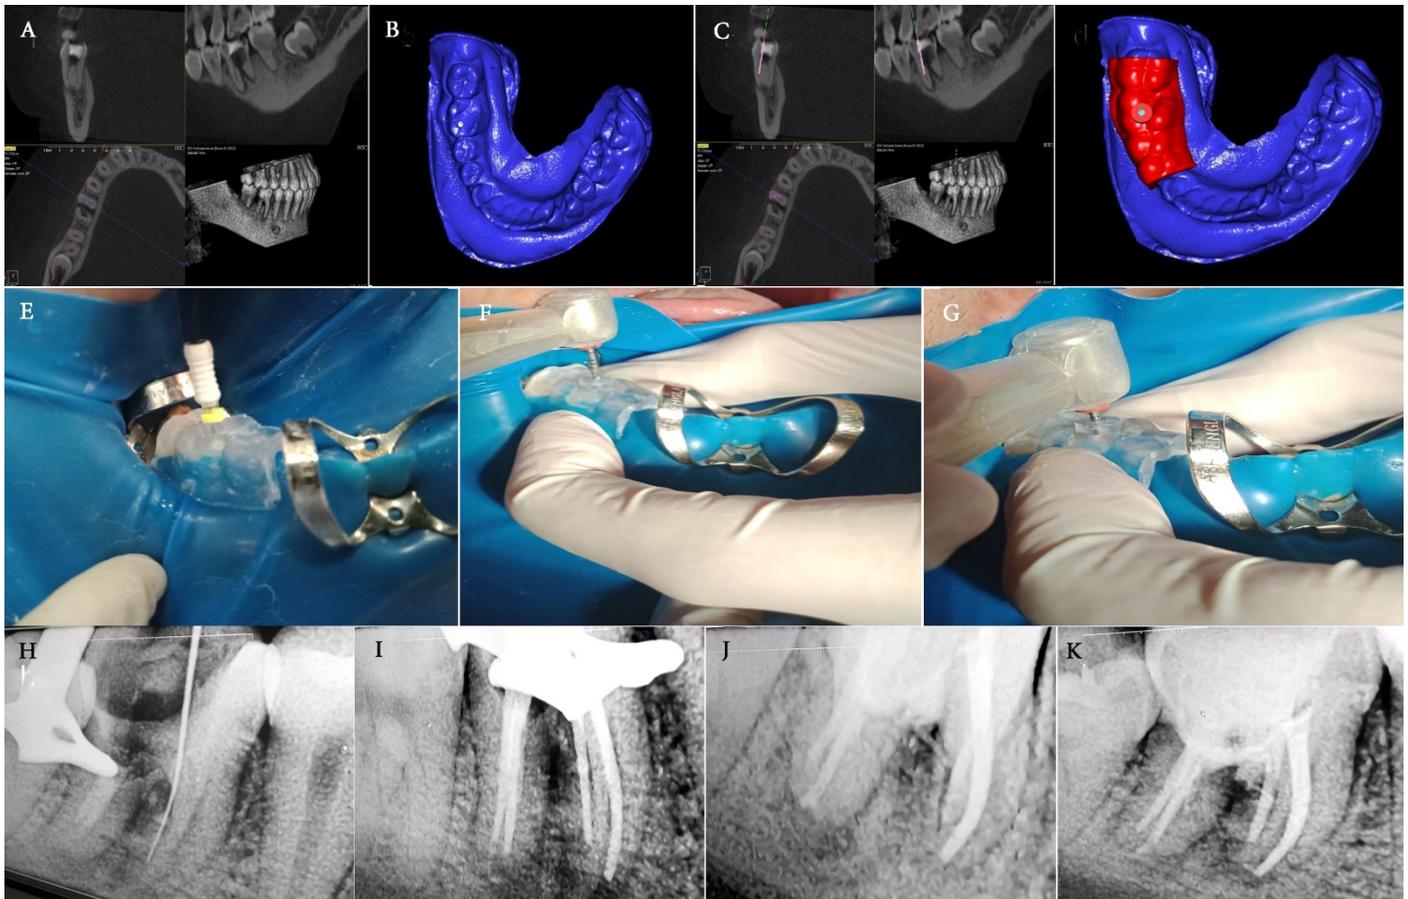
A) CBCT scan showing furcation perforation; B) STL file of cast scan of the mandibular arch; C) CBCT scan showing planning of the 3D endodontic guide; D) designing of the 3D endodontic guide; E) K-file #15 inserted through the 3D endodontic guide in the mesiobuccal canal; F) rotary file inserted through the 3D endodontic guide in the mesiobuccal canal; G) preparation of the mesiobuccal canal with the rotary file reaching the working length; H) periapical radiograph showing K-file #15 in the mesiobuccal canal; I) periapical radiograph showing the master gutta percha cones reaching the working length; J) immediate postoperative periapical radiograph showing the obturated canals and the MTA sealing the furcation perforation; K) Six-months follow-up periapical radiograph showing evidence of healing.
